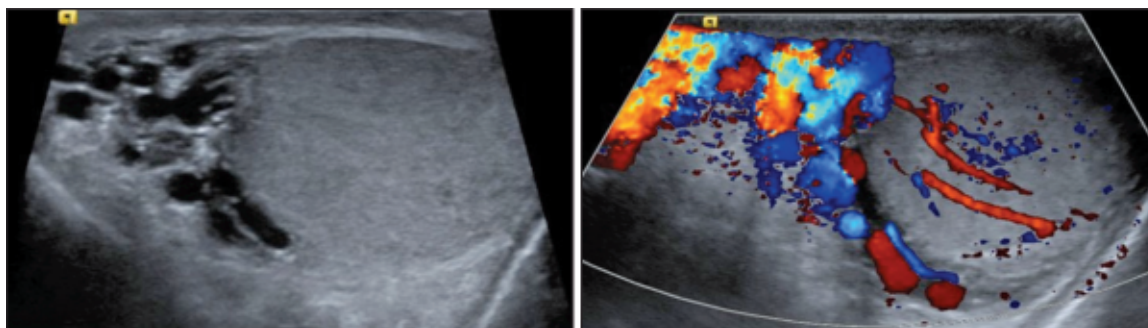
Ultrasonography of the left testicle demonstrating a large varicocele (left). Doppler ultrasonography with Valsalva maneuver (right).
